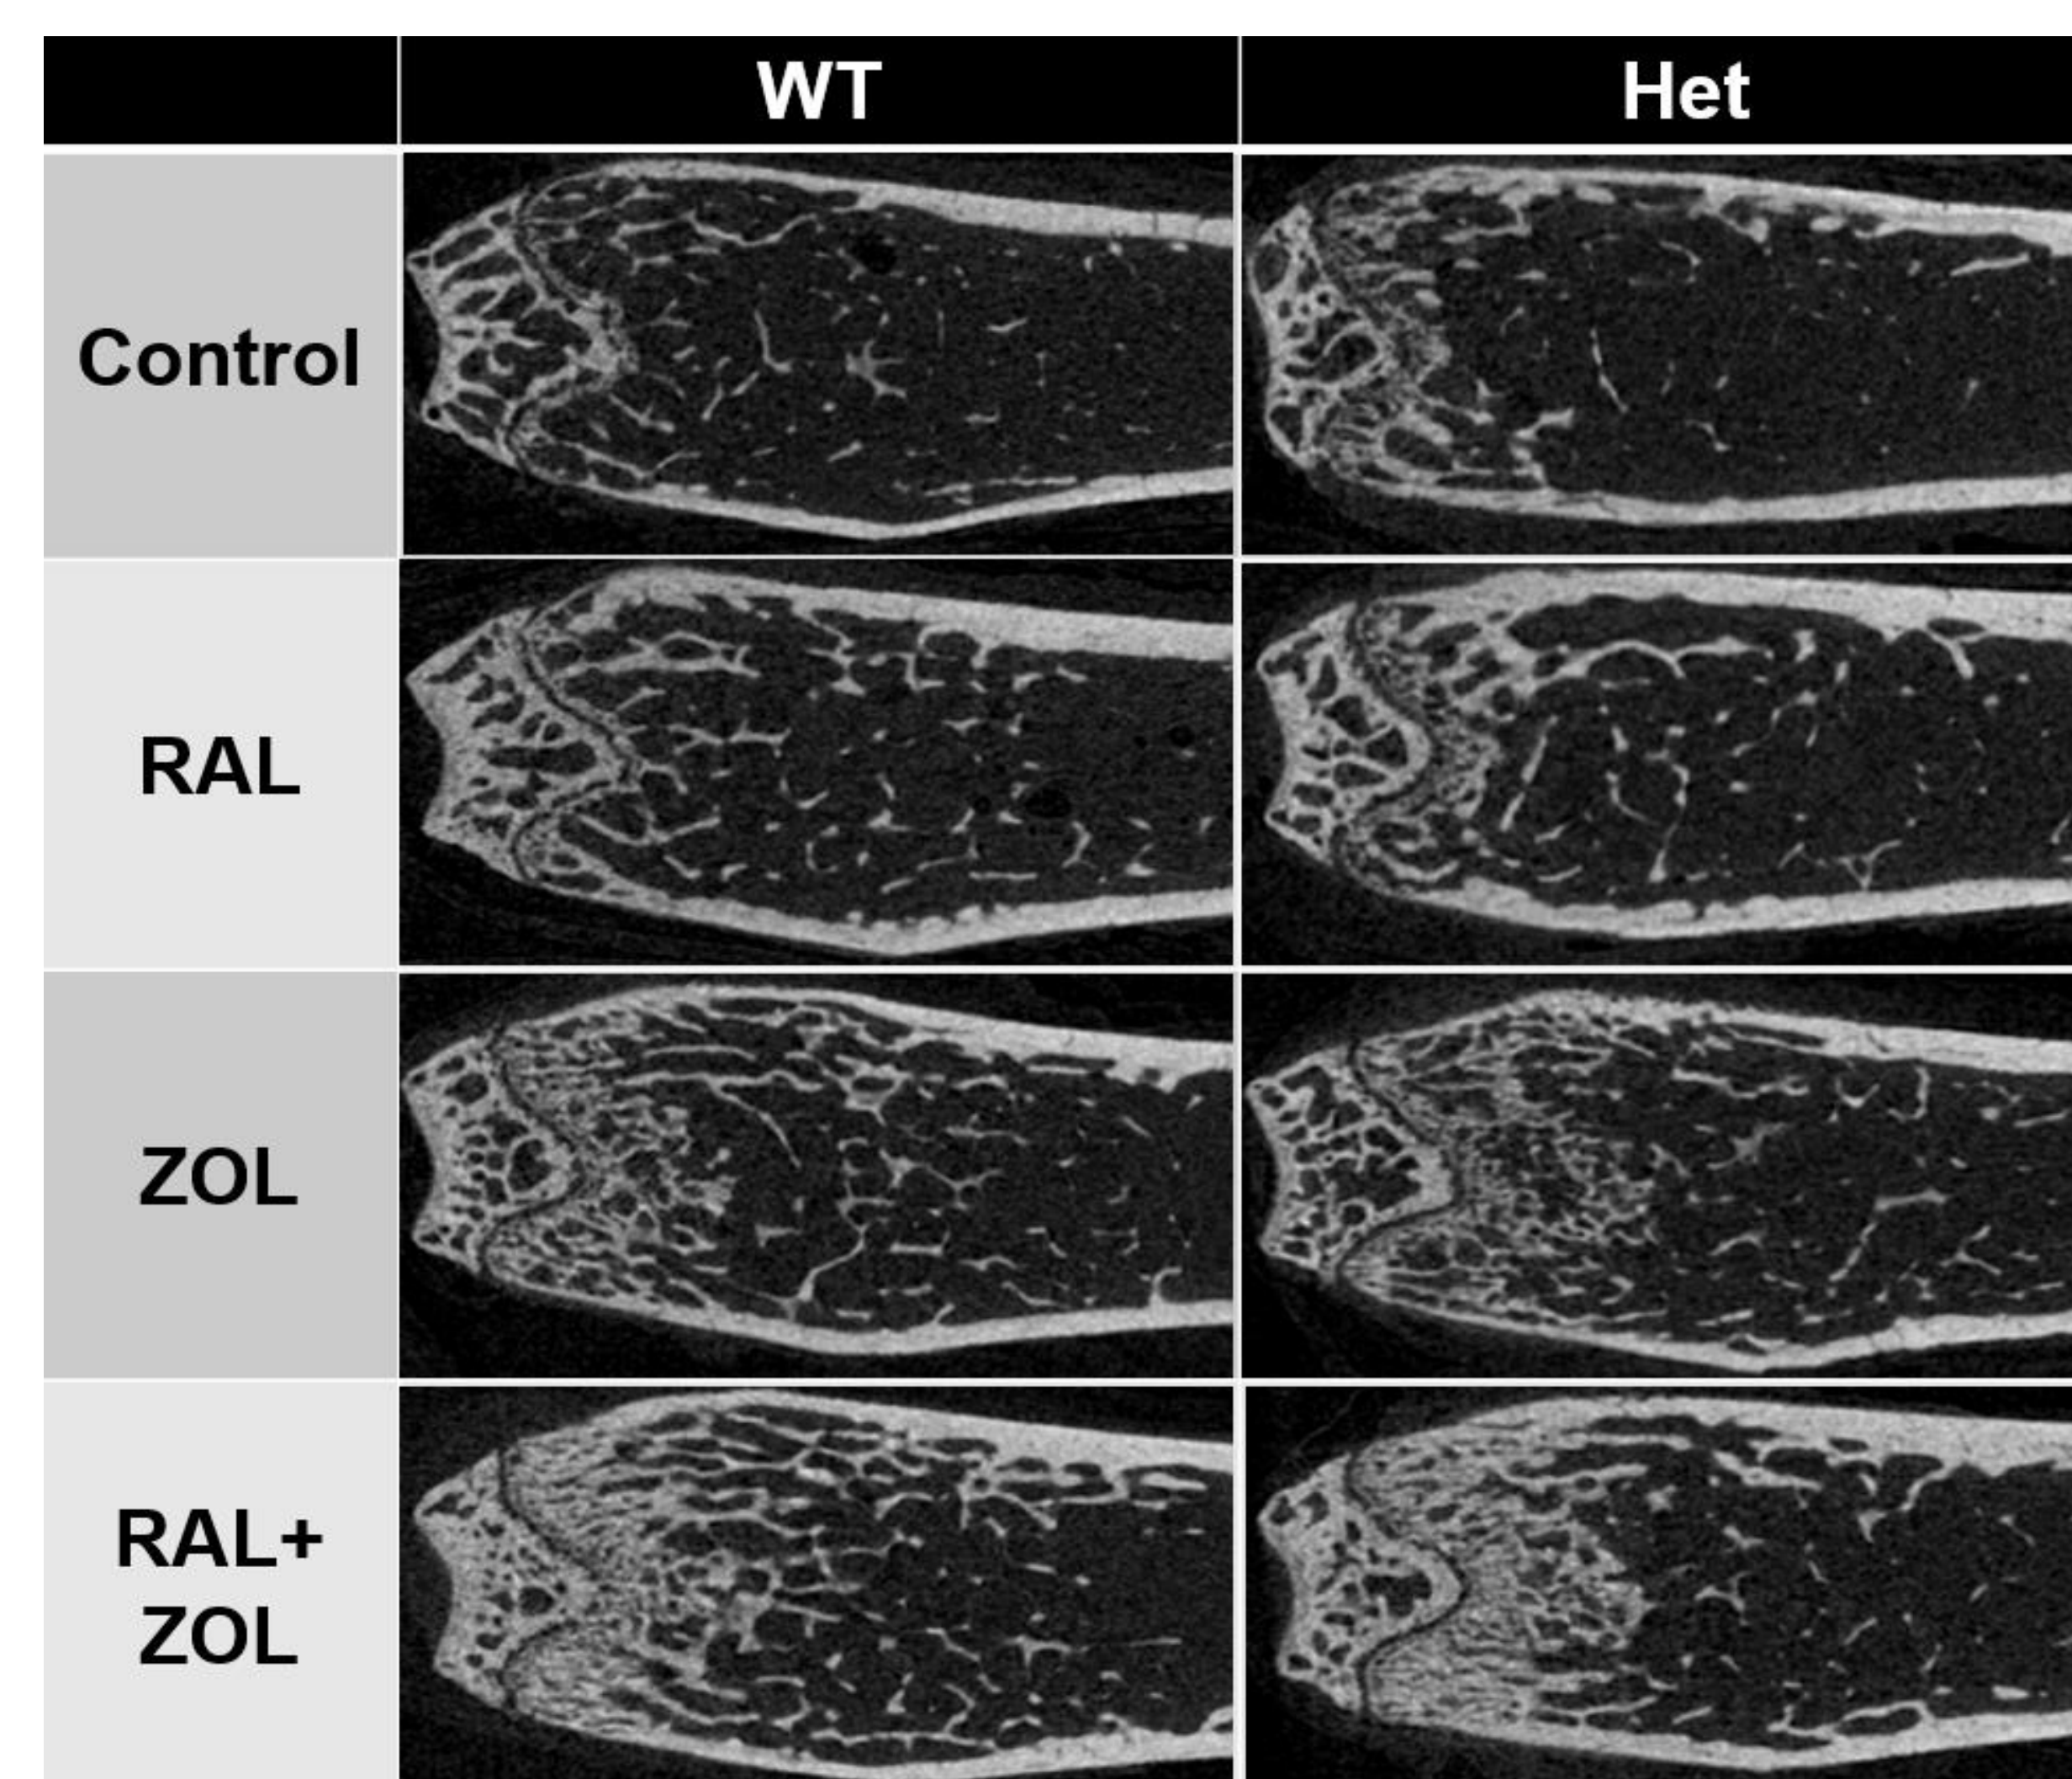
Distal femur CT images of each treatment for each genotype.
